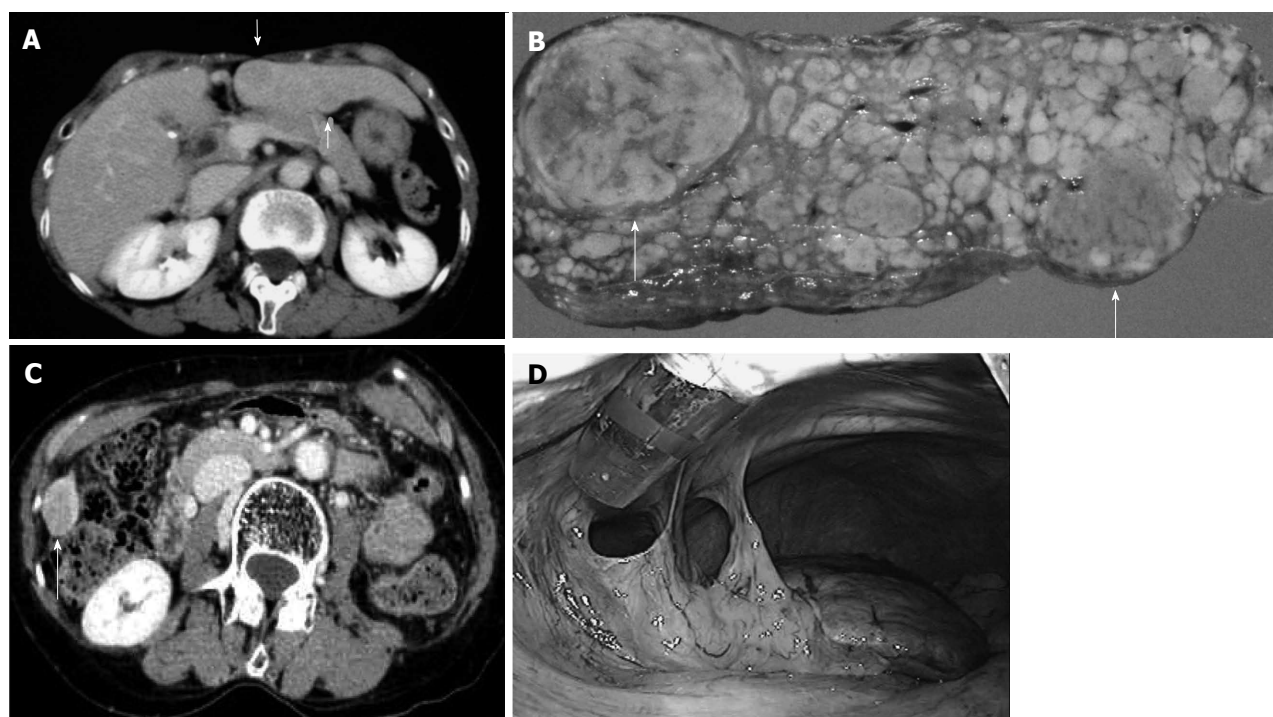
Repeat pure laparoscopic hepatectomy for patients with liver cirrhosis and hepatocellular carcinomas was feasible and safe: case 1. A: Computed tomography scan shows two hepatocellular carcinomas (HCC) in segment 3; B: The tumors (arrows) resected laparoscopically; C: A 69-year-old woman with type-C liver cirrhosis developed a new HCC on the caudal edge of segment 6 of the liver 2 years after the first hepatectomy; D: At the second laparoscopic hepatectomy, there was only mild adhesion around the resected area
